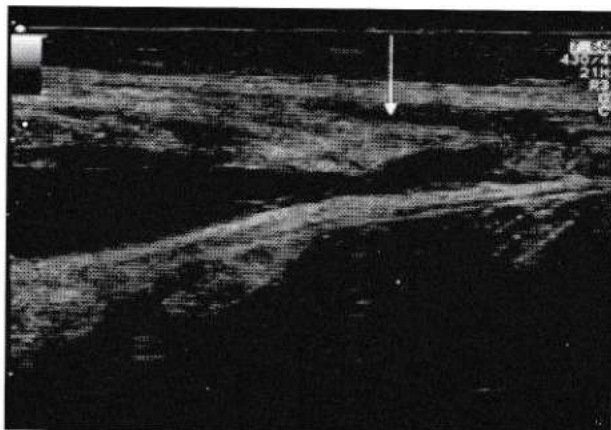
(A) Ultrasound of patient's left calf showing abscess. (B) Right calf, showing normal muscle appearance (M) with adjacent tibia bone (T).
